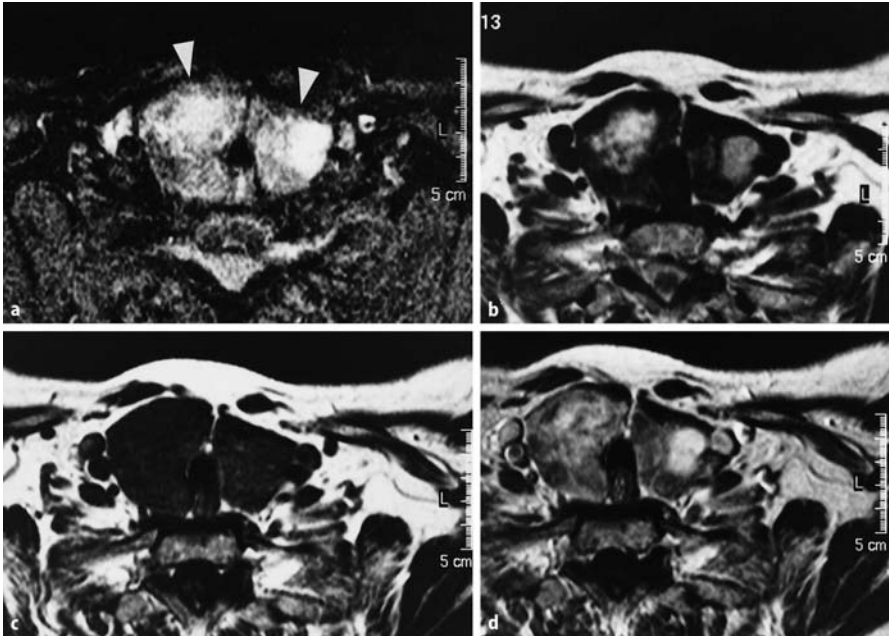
Multinodular intrathoracic goitre reaching down to the roof of the aortic arch (thyroid volume approximately 100 ml). The study was performed with the body coil, because the obese patient did not tolerate surface coils. a STIR: Inhomogeneous hyperintense enlargement of both thyroid lobes. b T2 TSE-weighted image: Multiple nodules of variable hyperintensity. Note: no flow phenomenon, compared with the STIR. c T1-weighted native image: Compared with the muscles, slightly hyperintense thyroid with discrete inhomogeneities, but no nodule distinguishable. d T1-weighted post-Gd image: multiple nodules with differing enhancement patterns become apparent
